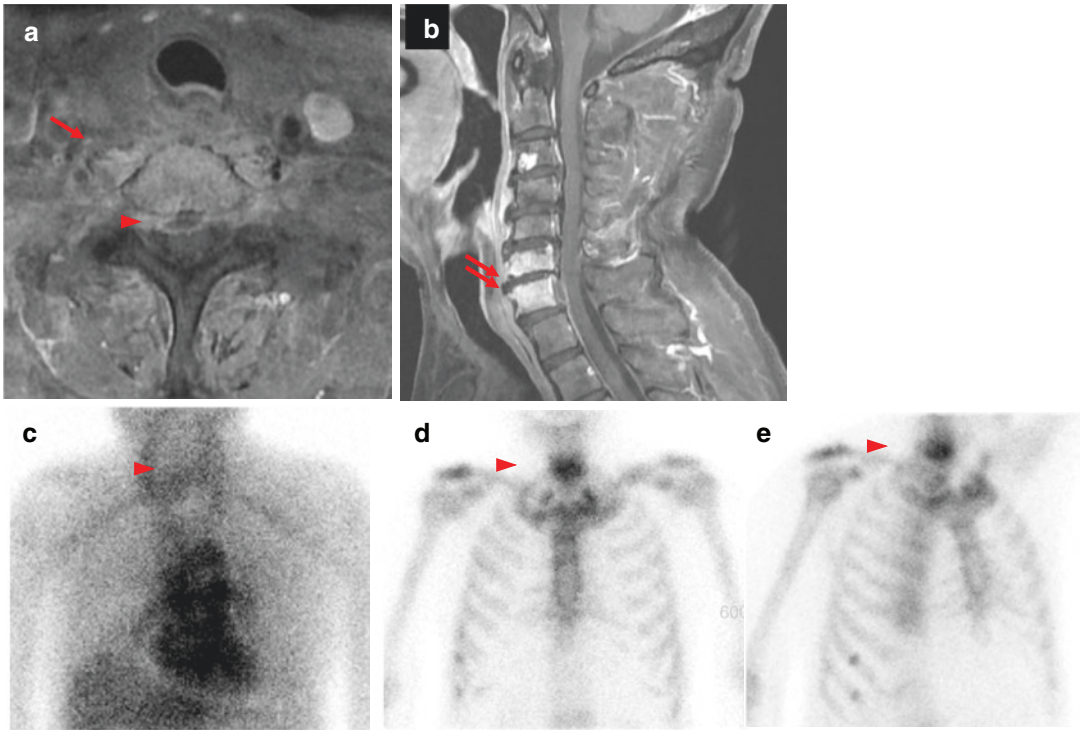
Contrast-enhanced MR images of C-spines show paravertebral abscess at the level of C4–C7 (arrow, double arrows in a, b) and anterior epidural abscess at the C6–C7 level (arrowheads in a). Suspicious mildly
